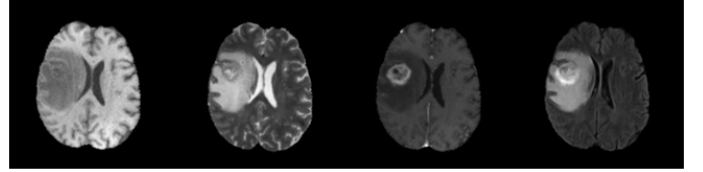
Different ways of viewing MRI images (from left to right the modalities are displayed: T1, T2, T1ce and FLAIR)
